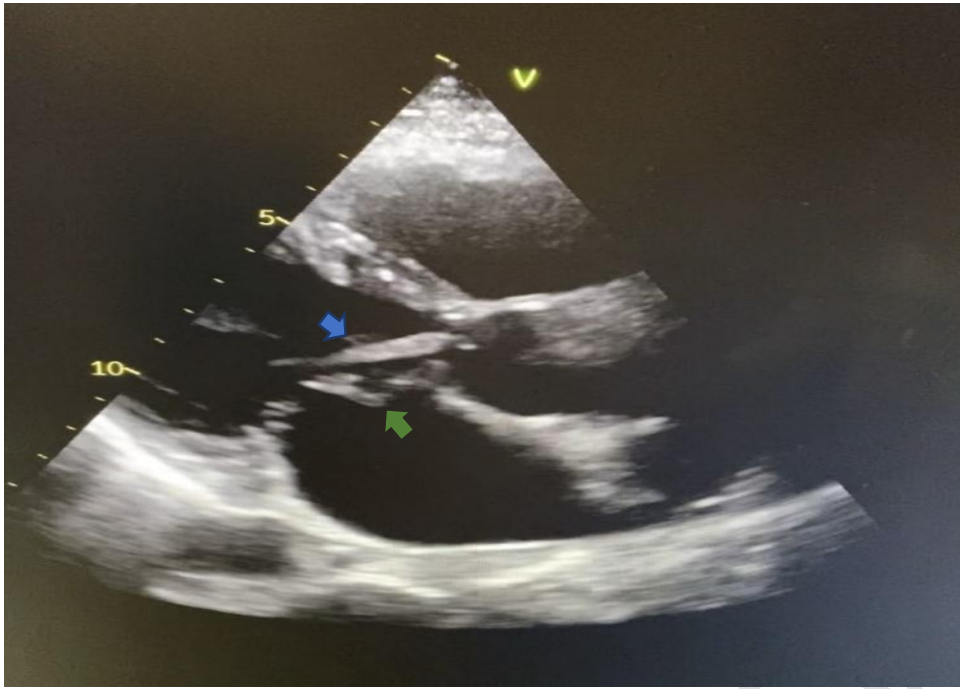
Transthoracic echocardiography showing the vegetation on the aortic valve (blue arrow) and abscess of the anterior mitral leaflet (green arrow)
